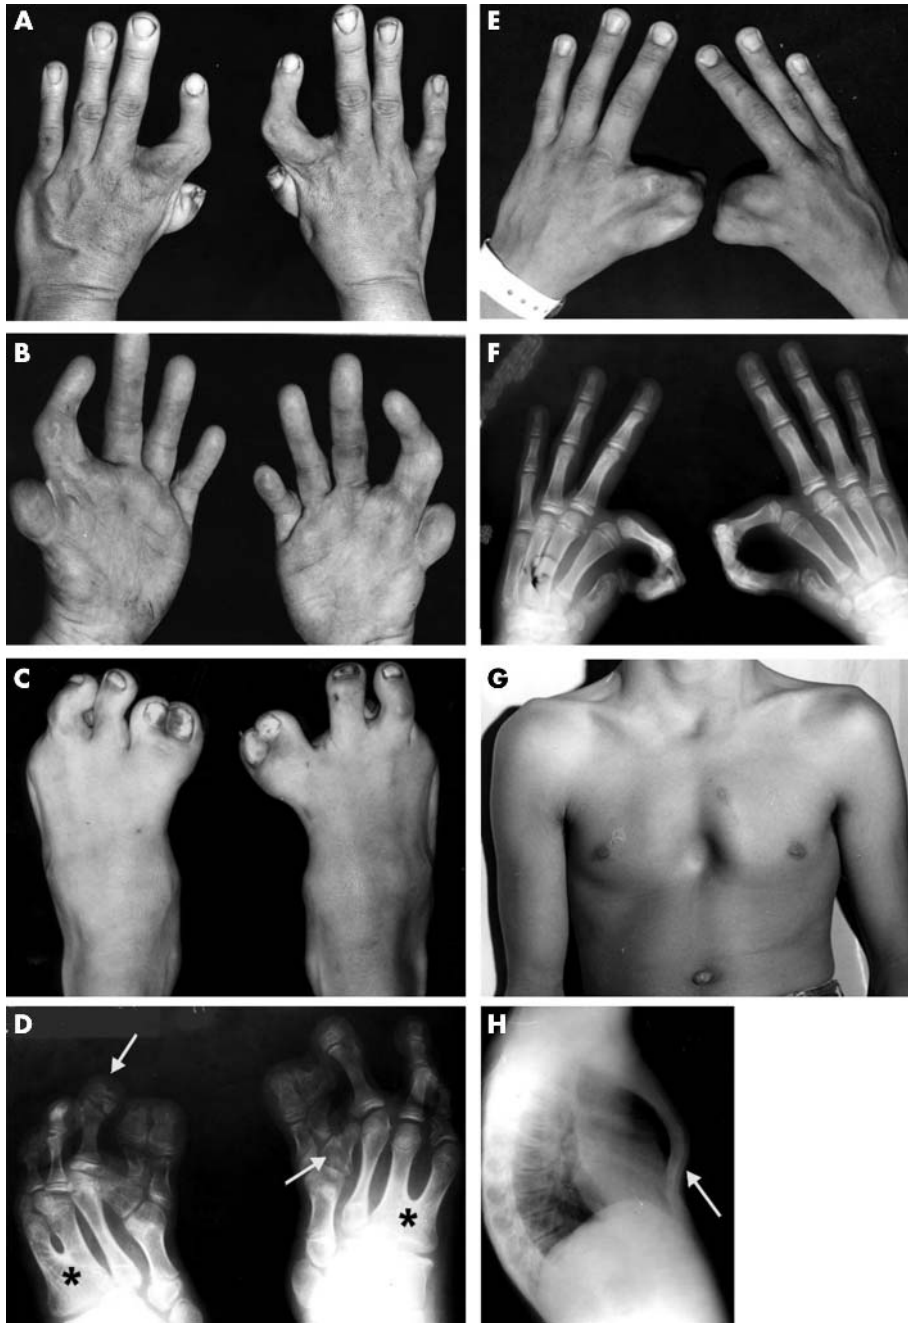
Phenotype of F syndrome. (A) and (B) show the hand phenotype of a relatively mildly affected individual. Note the severe shortening of the thumb and partial syndactyly with the second digit. (C) shows the foot phenotype with fusion of the first and second toes. (D) is an X ray of (C), demonstrating a single first metatarsal and duplication of the first toe phalanges. The duplicated toe has, however, three phalanges (arrow, patient's right foot) indicating that this is likely to be the second toe fused to the first. There is also duplication of distal phalanges in the other toes (arrow, left foot). In addition, there is fusion of metatarsals 3 and 4 at their proximal ends (*). (E) shows an affected hand with complete syndactyly between the first and second digits with the corresponding radiograph given in (F). (G) and (H) show a sternal deformity (arrow).
